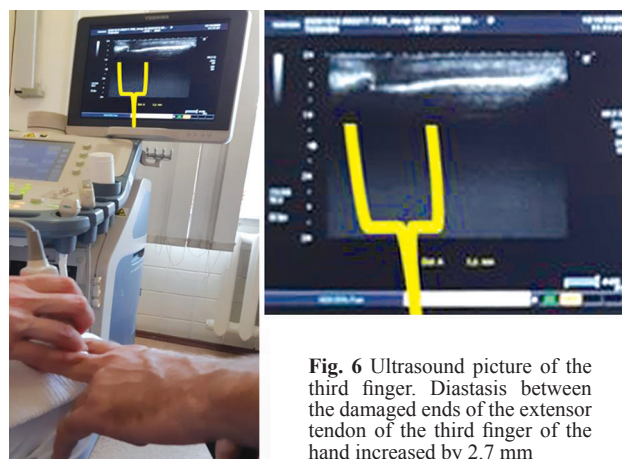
Ultrasound picture of the third finger. Diastasis between the damaged ends of the extensor tendon of the third finger of the hand increased by 2.7 mm
